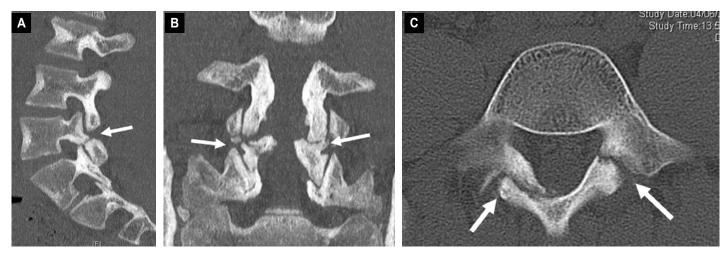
CT scan confirming bilateral chronic lysis on sagittal (a), coronal (b) and axial (c) views
